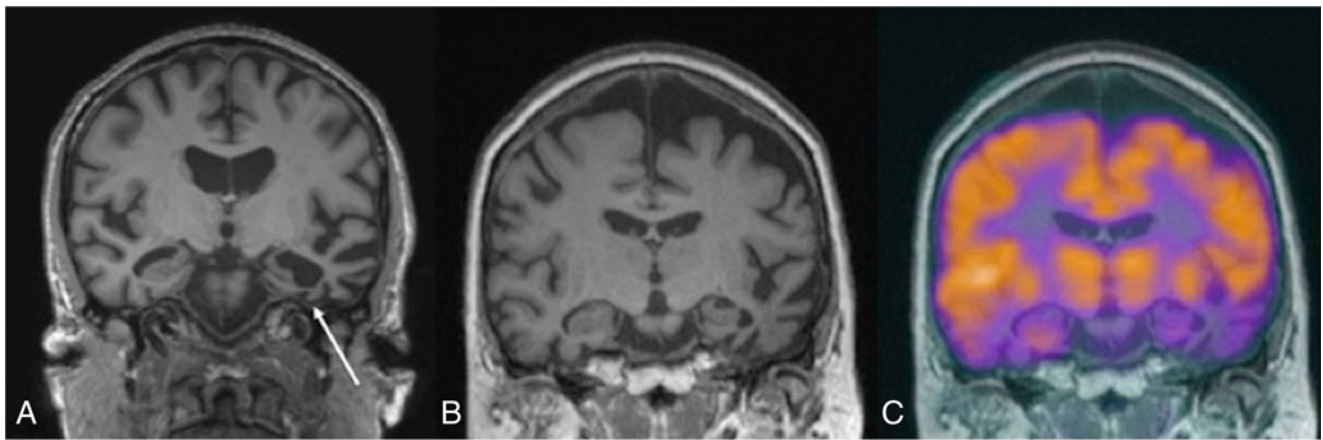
Coronal T1-weighted images (a, b) and fused FDG PET MRI image (c) in a patient with semantic variant PPA (semantic dementia). a, b Marked asymmetrical volume loss is found in the left temporal lobe affecting
